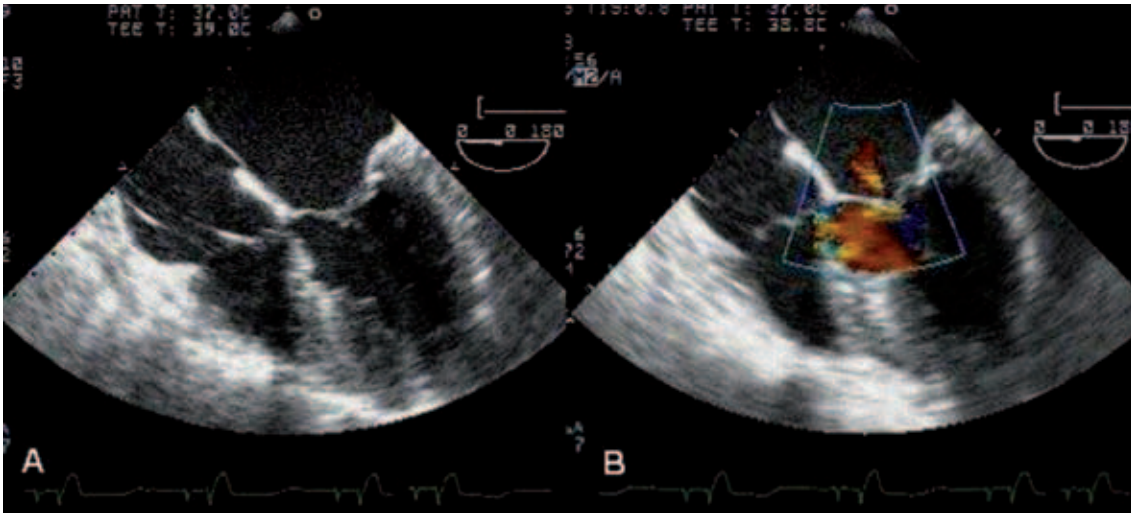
Transesophageal echocardiography images after bypass. (Midesophageal four chamber view). (A) Absence of systolic anterior motion. (B) Absence of mitral regurgitation (only a trivial jet of mitral regurgitation was recorded).
